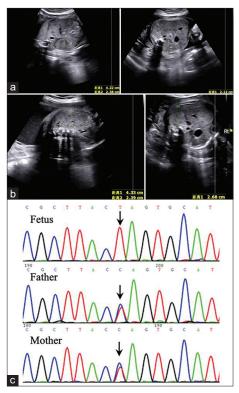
Prenatal ultrasound of a fetus with congenital nephrotic syndrome of Finnish type caused by a homozygous *NPHS1* variant c.2443C>T. Fetal ultrasound at 28 weeks of gestation shows a slight increase in size and echogenicity of the kidneys, with the left measuring 4.2 cm \times 2.3 cm \times 2.1 cm in length (a), the right 4.3 cm \times 2.3 cm \times 2.6 cm (b). DNA sequencing shows a homozygous *NPHS1* c.2443C>T variant in the fetus, a heterozygous state in both parents (c)
